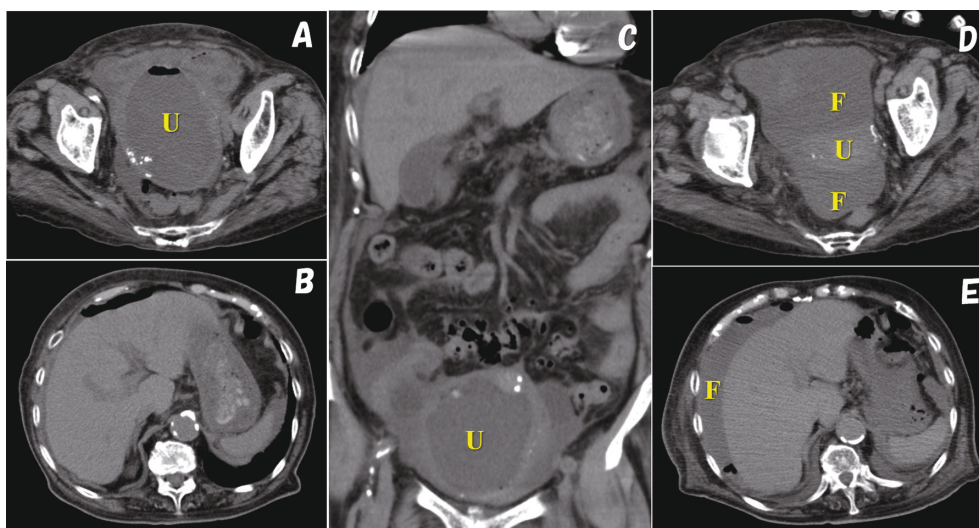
Preoperative urgent and repeat computed tomography (CT) in Patient 2. Urgent preoperative CT revealed a fluid collection and free air in the extremely dilated uterine cavity (A and C), although only a small amount of ascites was observed in the pelvic cavity (A, B, and C). Repeat CT revealed a collapsed uterine cavity and a large fluid collection in the pelvic cavity (D). The fluid collection came up to the level of the liver (E).
